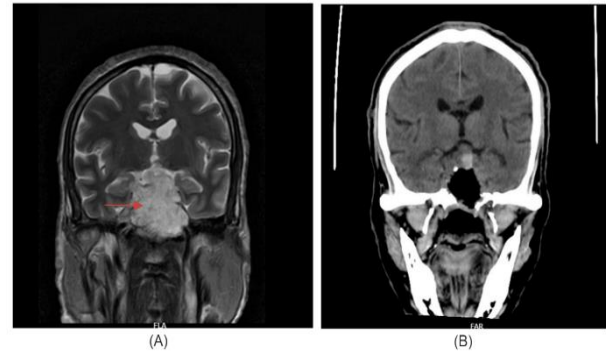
(A) Coronal section of pre-operative MRI brain showing hyperintense, minimally enhancing lesion in sellar and suprasellar regions (red arrow) compared with (B) Coronal section of post-operative CT.
